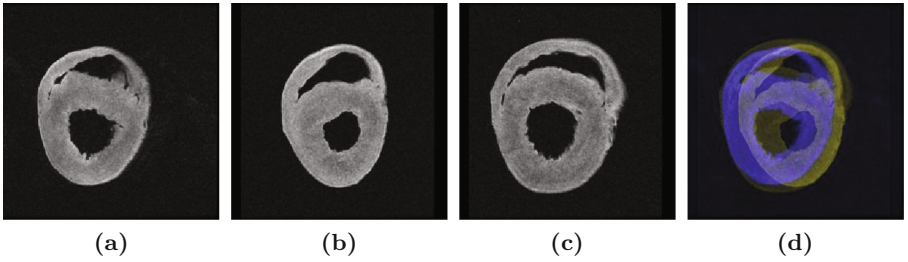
Variability of heart geometries. (a)–(c) The three anatomical MR images used in our data set and (d) the three hearts overlaid onto each other.
